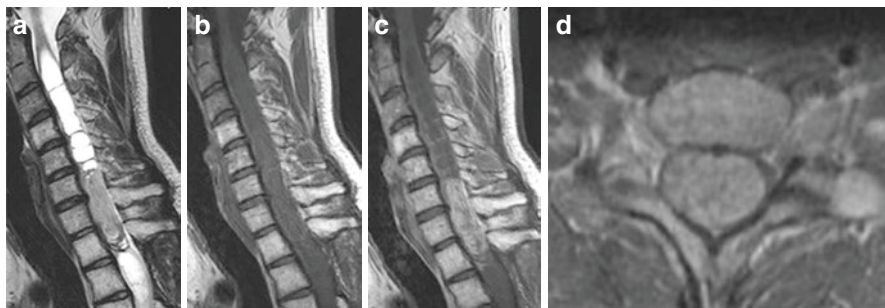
Pilocytic astrocytoma after partial resection. Sagittal T2-weighted (a), T1-weighted (b), and contrast-enhanced T1-weighted (c, d) images demonstrating completely solid tumor with moderate contrast enhancement and an associated syrinx in the cervical cord
